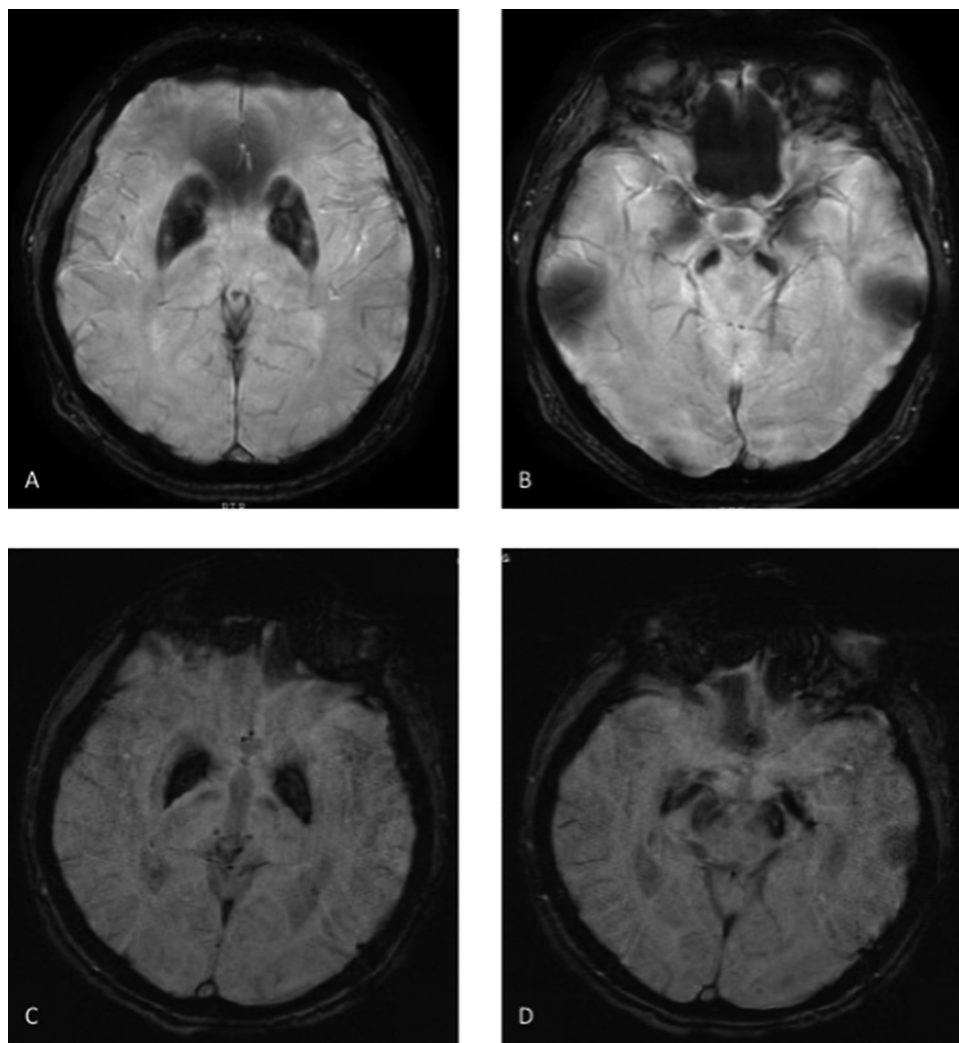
Brain MR images of the case 1 and 2. The axial susceptibility-weighted angiography (SWAN) MR images demonstrating hypointensity of the globus pallidus (A) and substantia nigra (B) that indicate iron accumulation in case 1. The susceptibility weighted imaging (SWI) axial images demonstrating hypointensity of the globus pallidus (C) and substantia nigra (D) that indicate iron accumulation in case 2.
